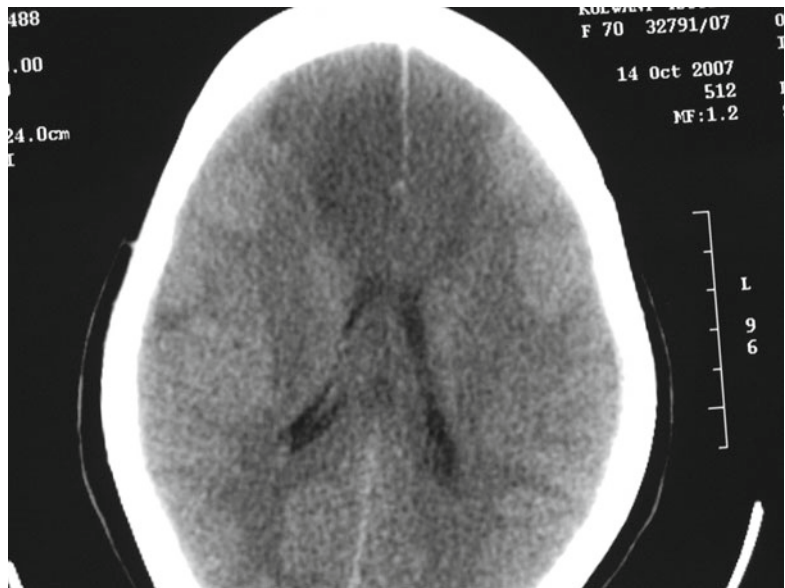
Axial section of plain CT scan showing hypo-densities in bilateral ACA territories visualized after 72 h of pituitary apoplexy
